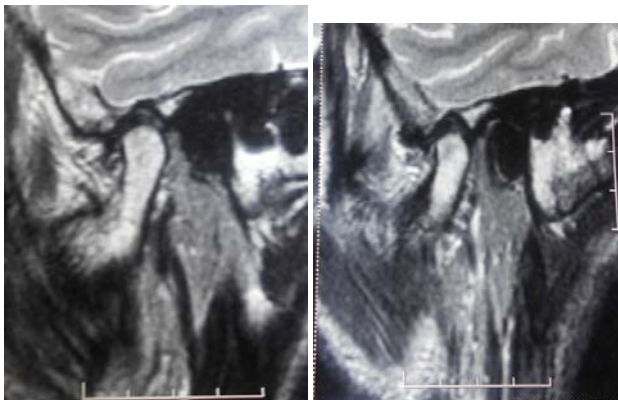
MR image showing normal disc-condyle relationship in closed mouth position and open mouth position.
